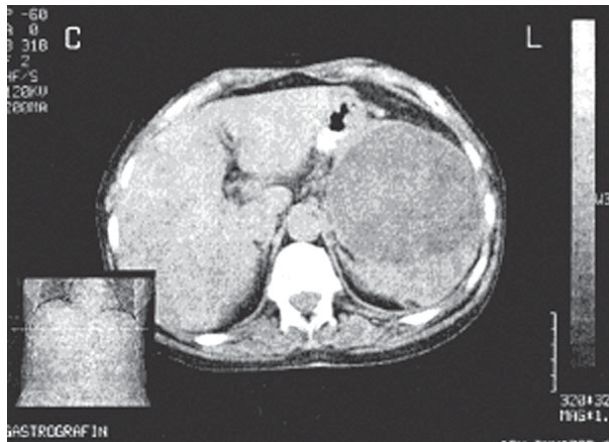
Abdominal CT scan showing a large pseudocyst of the pancreatic body and tail, 80 mm in diameter, with expansive effect to the surrounding structures, especially the spleen and stomach (six months before drainage).
